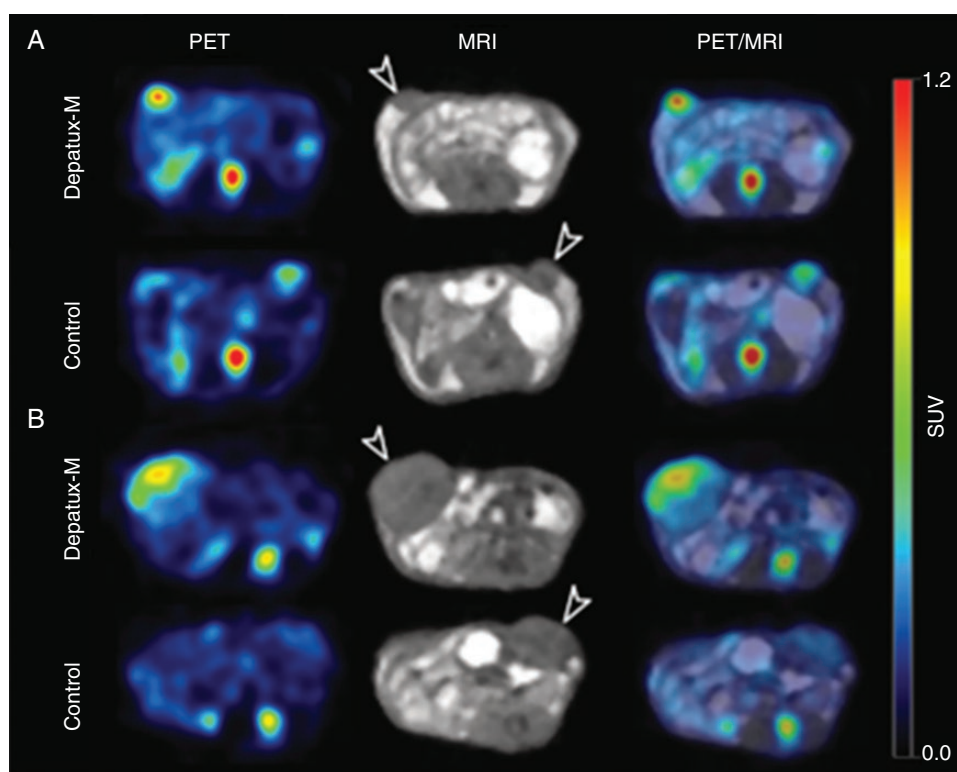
PET/MR imaging with ^{89}Zr -Df-ABT-414-ADC and ^{89}Zr -Df-isotope control in (A) small versus (B) large tumours on D3 postinjection. White arrows indicate location of the tumours. Maximal uptake in the small tumours (A, PET image) is higher than that in the large tumours (B, PET image) confirmed on quantitative analysis.
